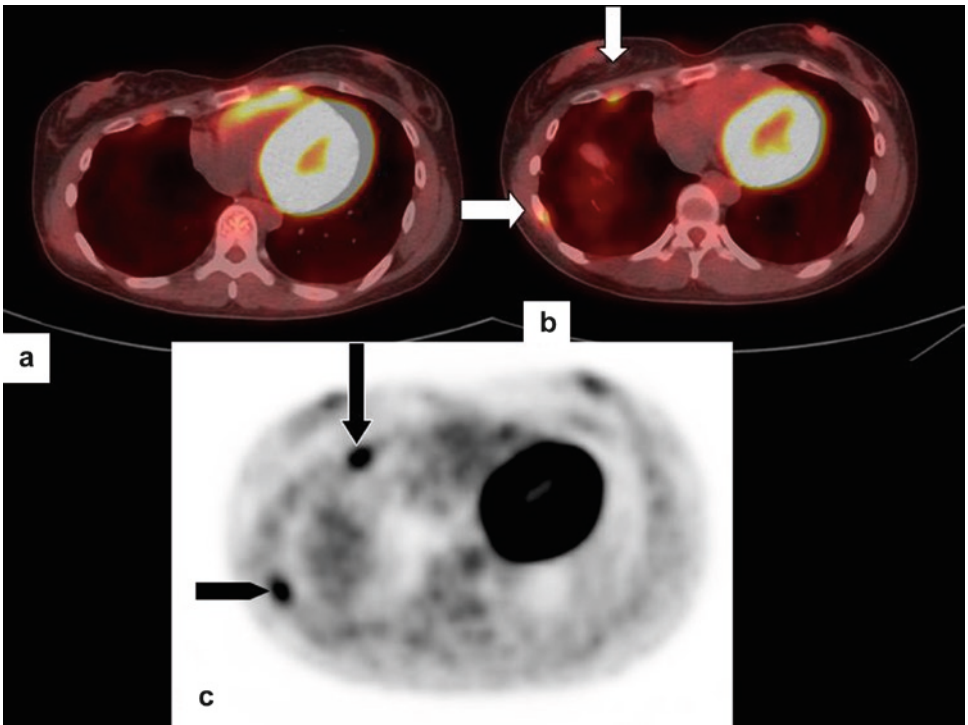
(a) Baseline fused ^{18}F -FDG axial image post right radical pleurectomy (b) (*white arrows*) and (c) (*black arrows*) 50% increase in SUV; these two areas were subsequently resected
